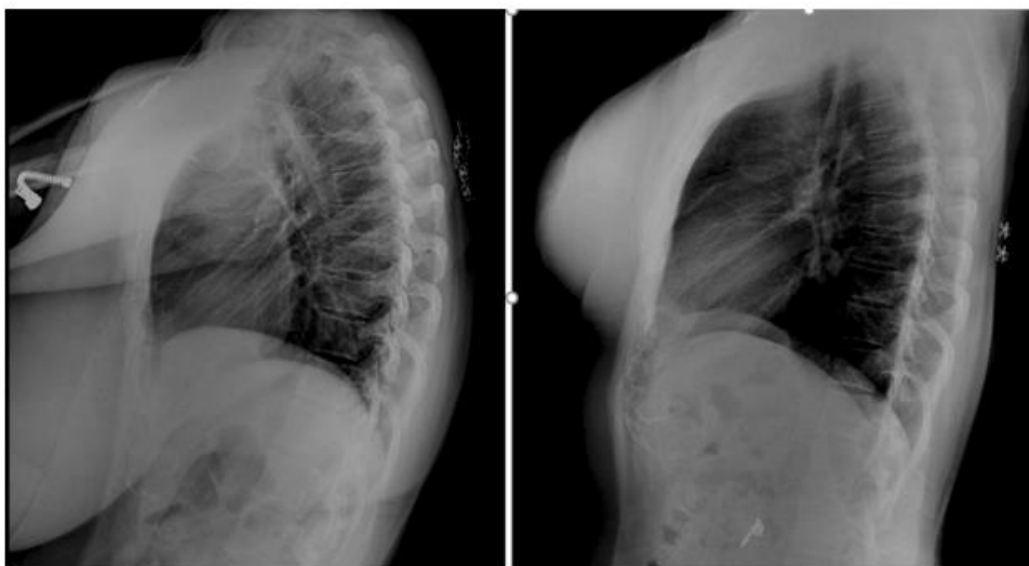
Correction of thoracic kyphosis on lateral spinal radiography (Yücel *et al.* 2024)
